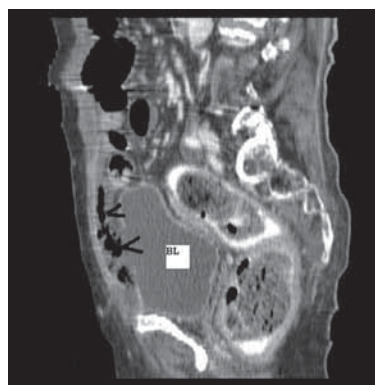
Sagittal Reconstructed CT Image
